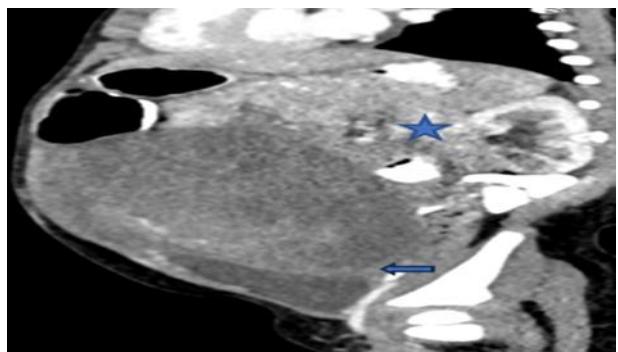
Computed tomography of the abdomen (sagittal section) shows the extensive omental caking (blue asterisk). It is abutting the urinary bladder inferiorly (blue arrow).
